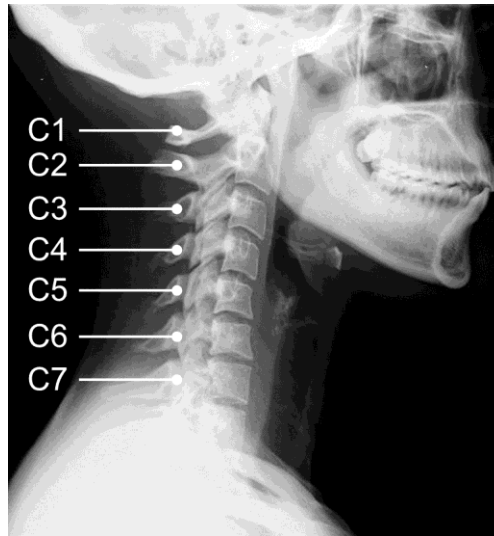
LATERAL RADIOGRAPHY OF THE CERVICAL SPINE
